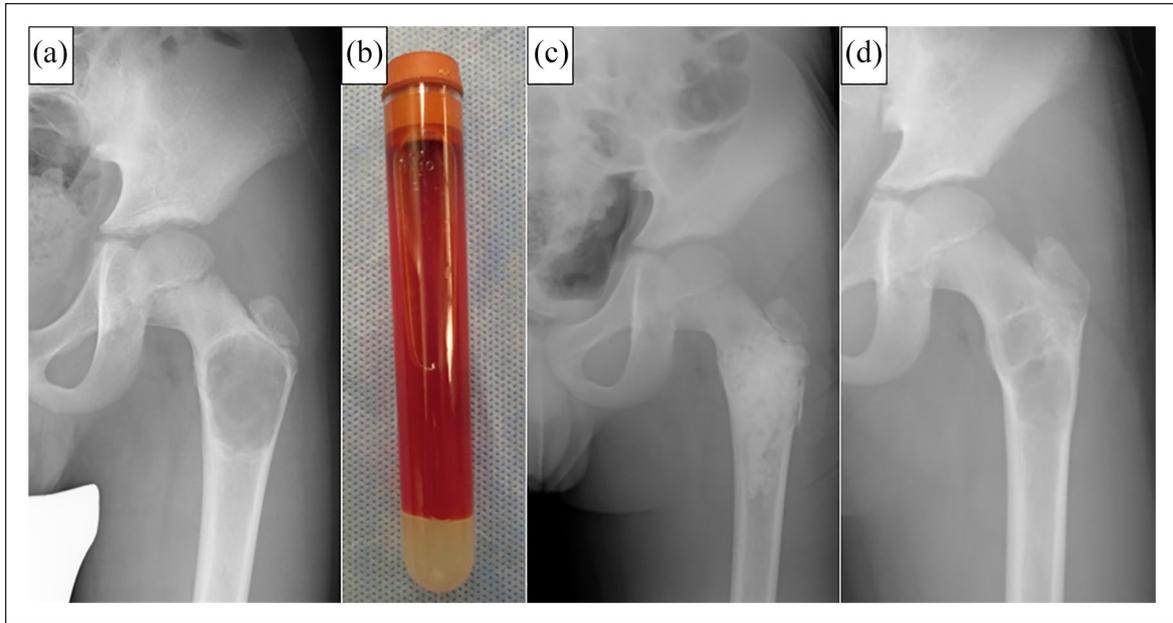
Case 22: An 8-year-old male patient. (a) Plain radiographs demonstrate an active-phase solitary bone cyst in the left proximal femur. (b) Gross finding of aspirated cystic fluid is serosanguineous. (c) At surgery, curettage and artificial bone grafting using beta-tricalcium phosphate (β -TCP) are performed. (d) Postoperative recurrence occurs 19 months after the surgery. Additional surgery is performed for this patient.
